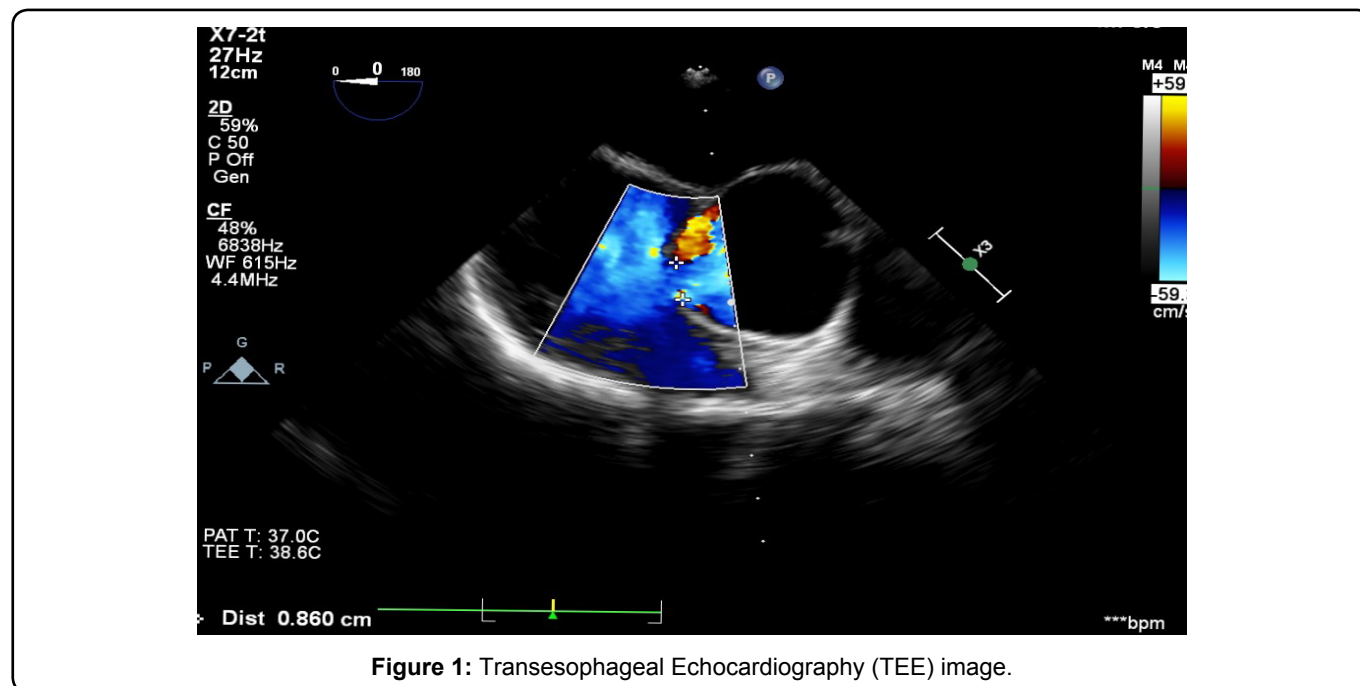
Transesophageal Echocardiography (TEE) image.
